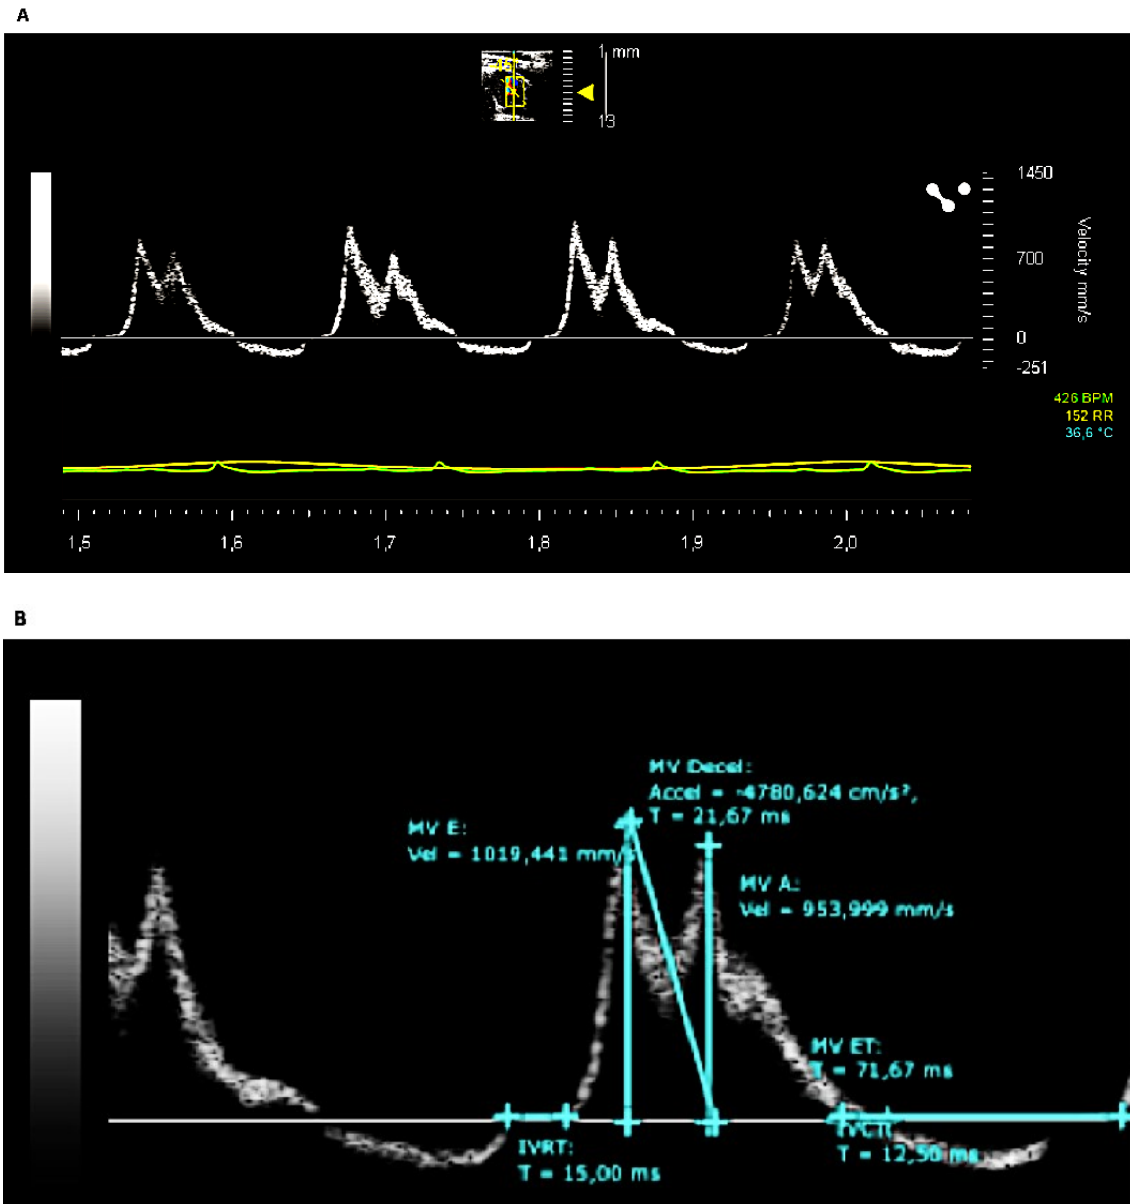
Pulsed wave Doppler:
